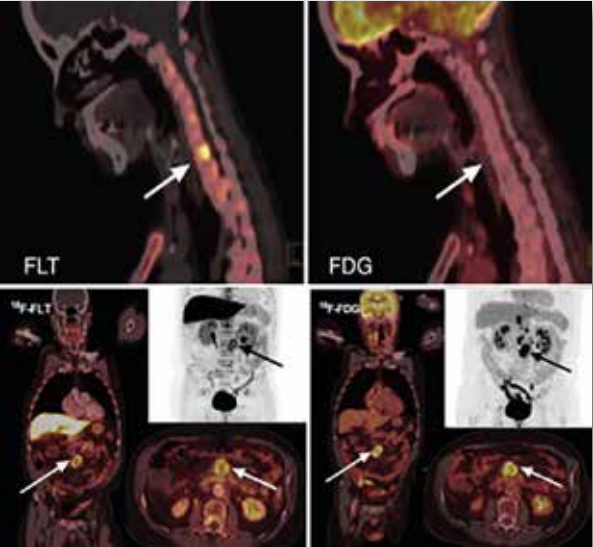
Figure showing head-to-head comparison of ¹⁸F-FLT and ¹⁸F-FDG in neuroendocrine tumor (NET) patients. Upper panel: Bone metastasis (arrows) from small intestinal NET seen on ¹⁸F-FLT, but not on ¹⁸F-FDG PET. Lower panel: Primary NET (arrows) seen on both ¹⁸F-FLT and ¹⁸F-FDG, but additional foci only seen on ¹⁸F-FDG (from Bardram C et al. J Nucl Med 2017)
